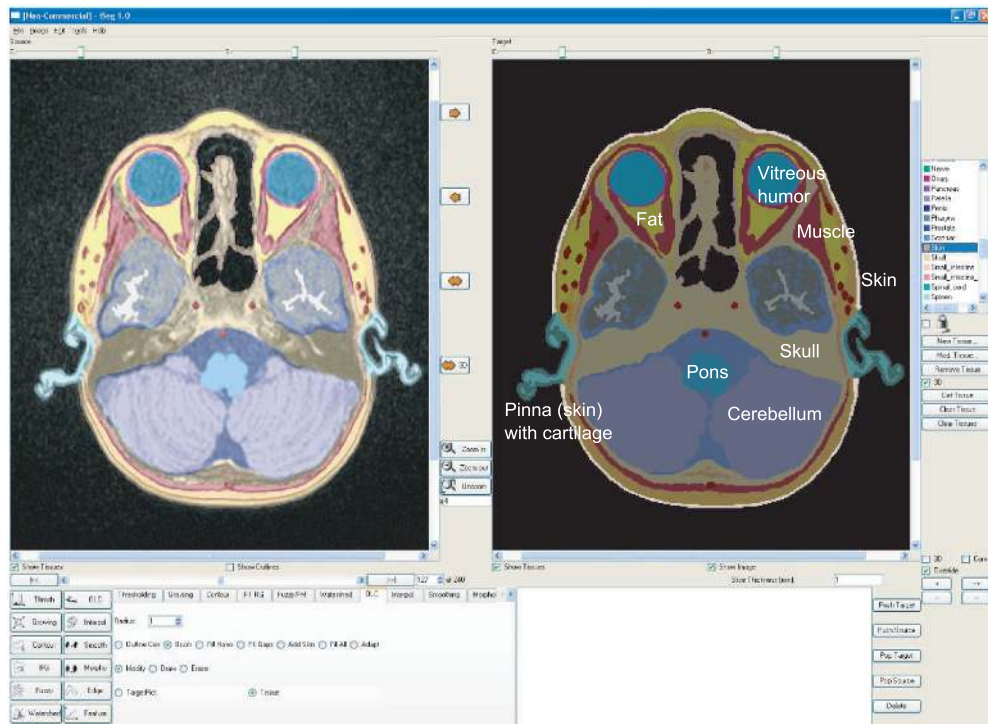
Segmentation of the MR images using the software iSEG.
